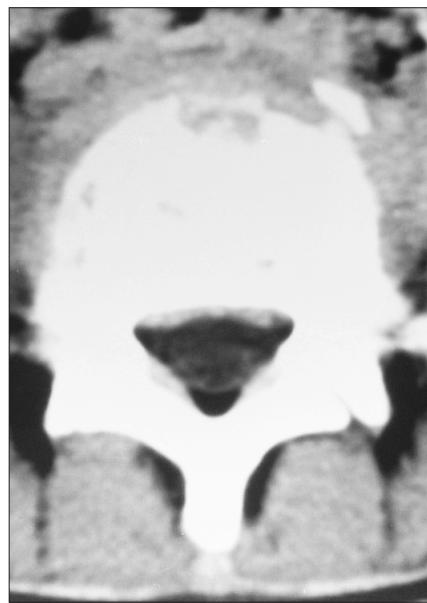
Computed tomography (CT) scan at the L4 level showing destruction of the vertebral body, and a small paravertebral mass.
